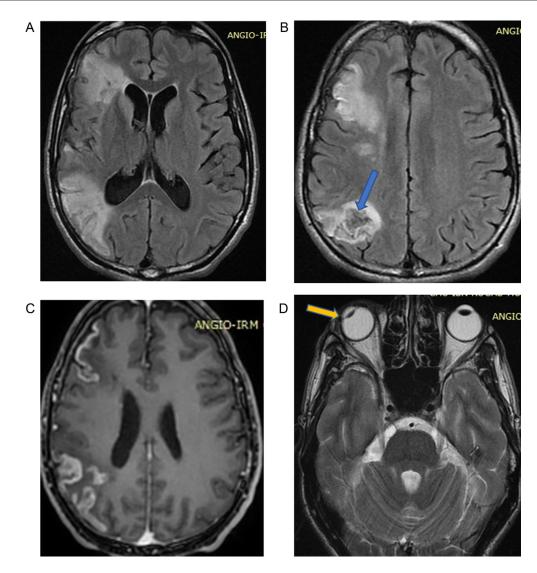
Brain MRI in Flair, T2*, 3D T1 after injection of Gadolinium and T2 axial sequences (A, B, C, and D): Right frontal and temporo-occipital folds, in Flair hyper signal, with areas of signal void in T2* (blue arrow), associated with a contrast of the right hemispheric cortical ribbon after injection of Gadolinium. There is also exstrophy of the right eye (orange arrow) (Color version of figure is available online)
